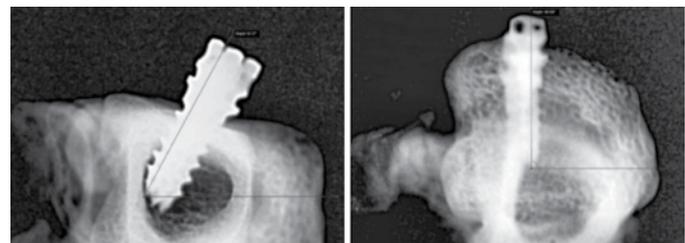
Radiograph showing the angulation of the miniscrews
